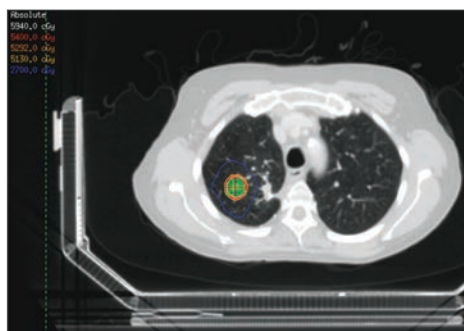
Axial computed tomography (CT) image of an early-stage NSCLC of the right lung. Isodose curves depict the tumor receiving the curative dose.
